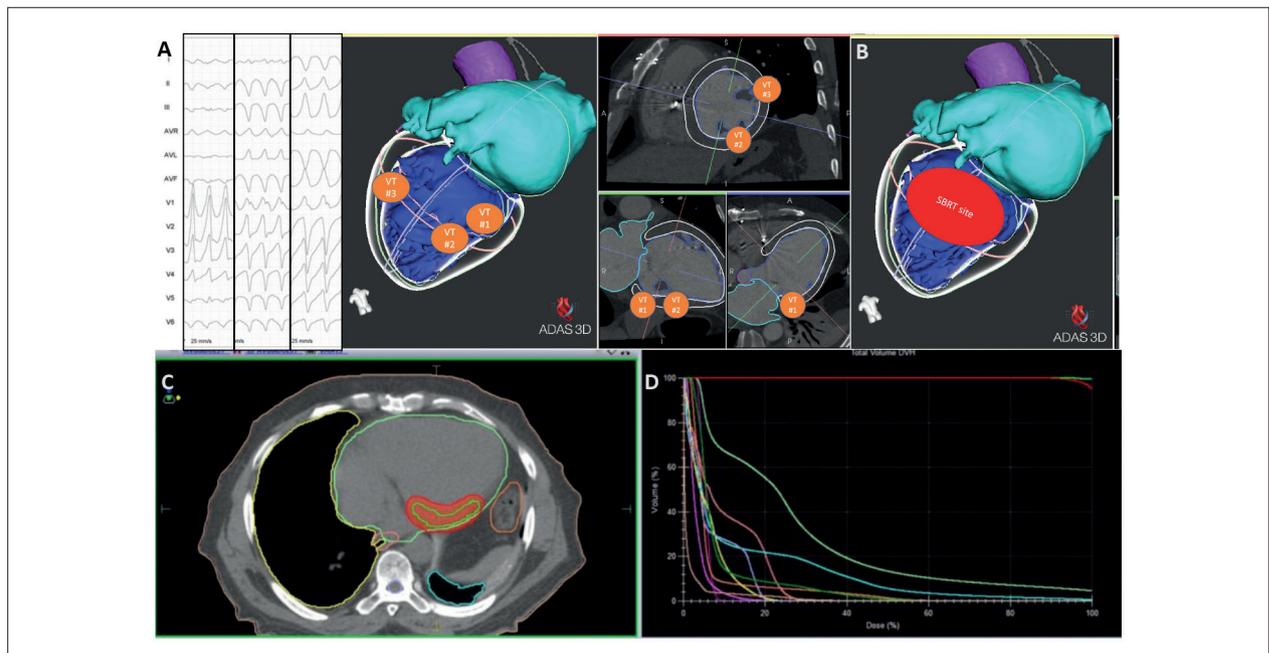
Radiation therapy planning. Ventricular tachycardia morphologies induced in the electrophysiological study (A) were analyzed, and the exit site was demarcated on the three-dimensional reconstruction of computed tomography scans and, once exit sites were demarcated, there was the definition of the area to be irradiated (B). The defined area was then manually demarcated in the radiation therapy system (C), which calculated dose constraints for each surrounding structure (D).
